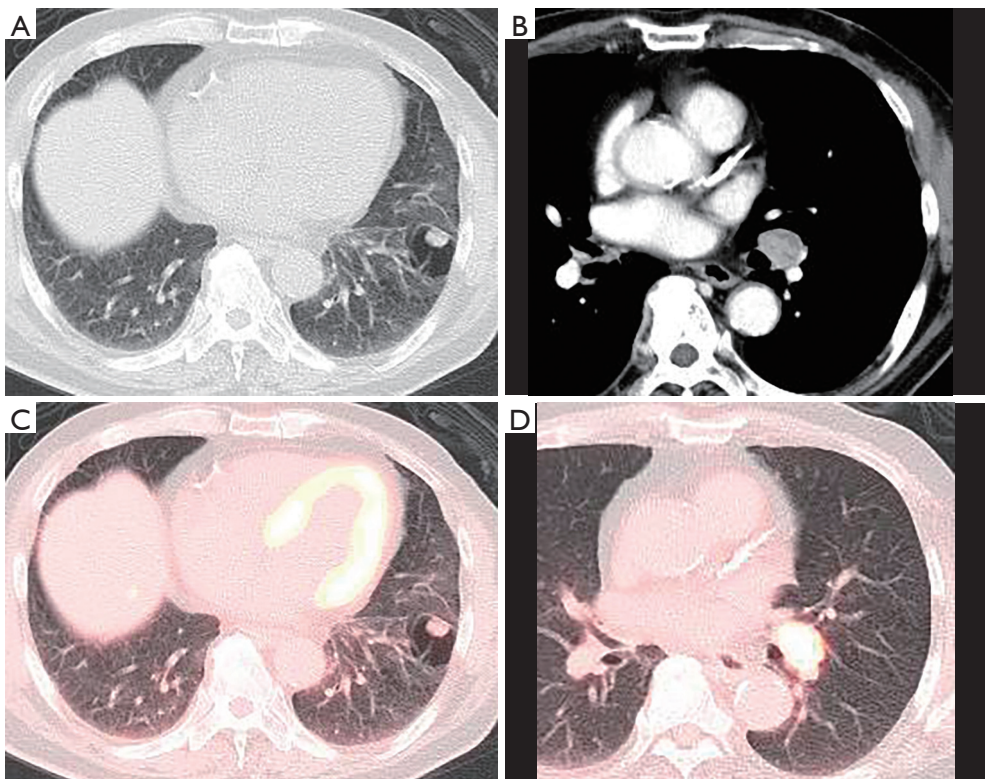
Chest computed tomography and positron emission tomography at presentation. (A) A 1.5-cm nodule was found in a cavity in the left lower lobe; (B) computed tomography revealed swelling of the interlobar lymph node; (C,D) fluorodeoxyglucose (FDG)-positron emission tomography showed FDG accumulation in the intracystic nodule and the interlobar lymph node. FDG accumulation was more intense in the interlobar lymph node than in the intracystic nodule.
